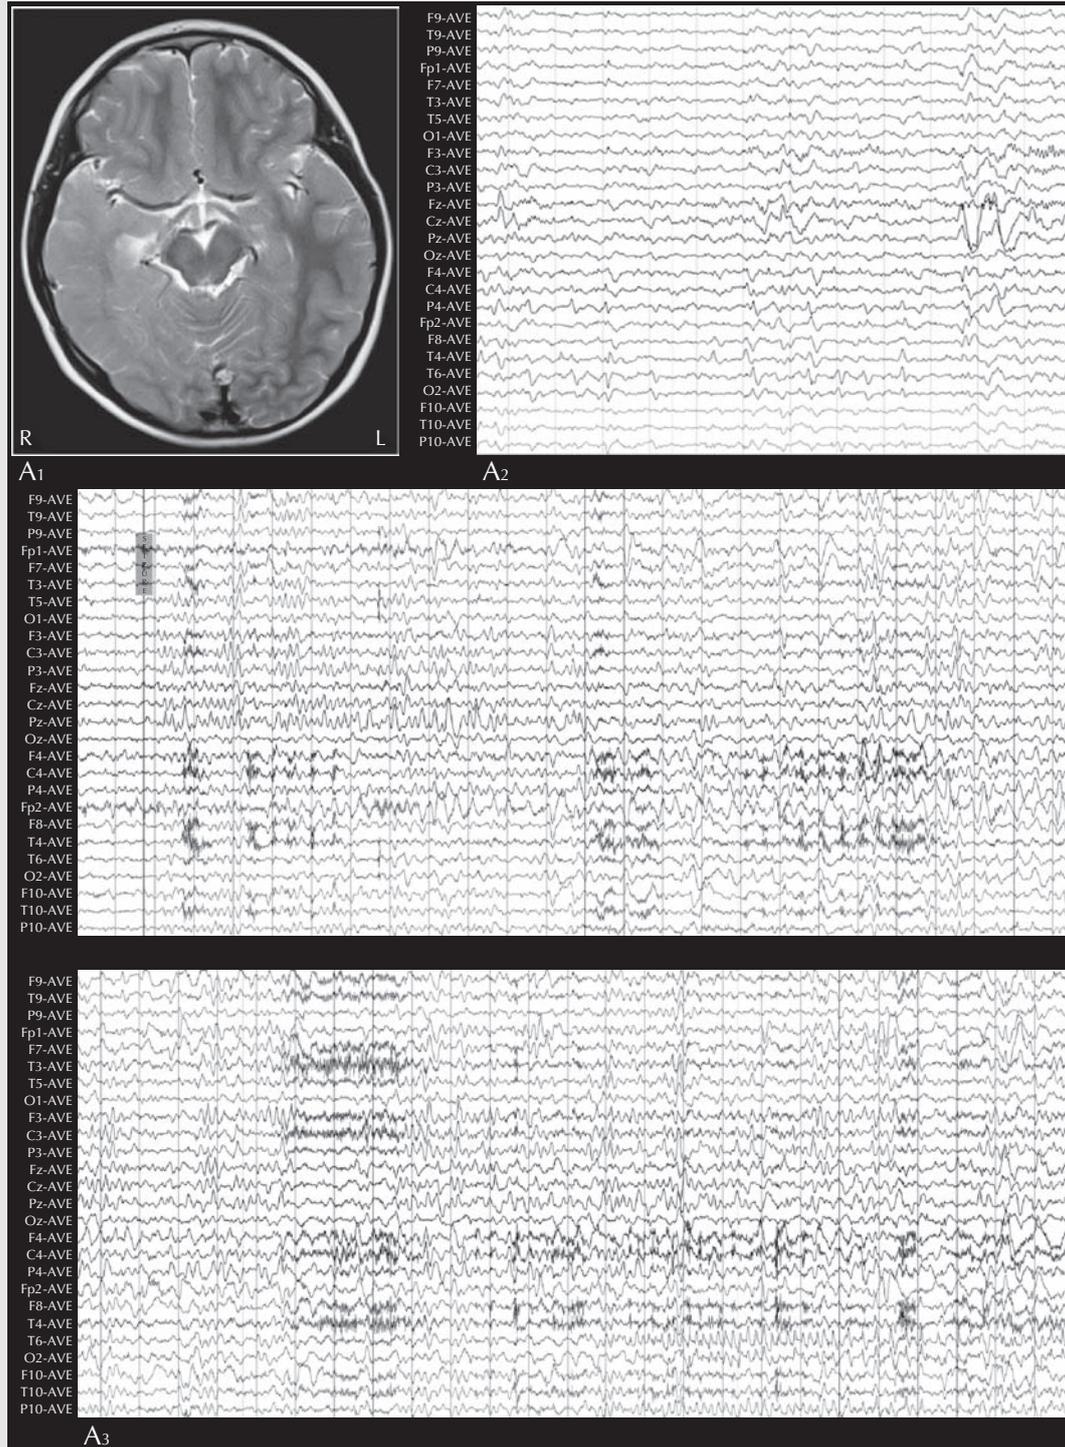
Patient 3. (A₁) MRI showing extensive right temporal lobe FCD, involving the pole, the medial-basal and lateral temporal neocortex, extending back towards the occipito-temporal junction. (A₂) Interictal EEG reveals a right mid-posterior temporal SW focus (T4/T6), occasionally extending to the anterior temporal region (F8/Fp2). (A₃) Ictal EEG shows a broadly distributed onset of semi-rhythmic “delta” pattern over the right frontal region and the anterior midline (Fp2/F4/Fz).
